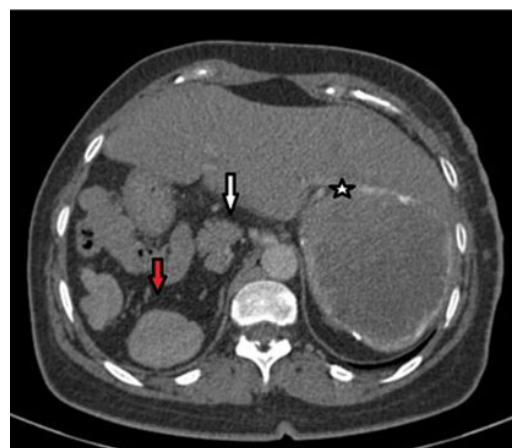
Enhanced abdomino-pelvic CT scan at the portal phase showing abdominal situs ambiguus with short pancreas (white arrow) and polysplenia (red arrow). Note liver hydatid cyst (star) which was incidentally discovered in our patient.
